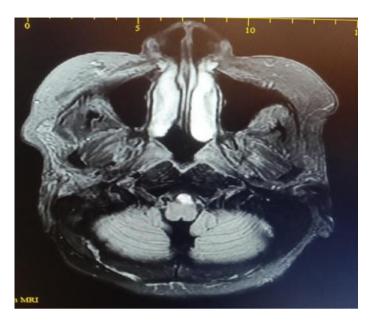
MRI brain (axial view) showing multiple supra and infratentorial lacunar infarcts
